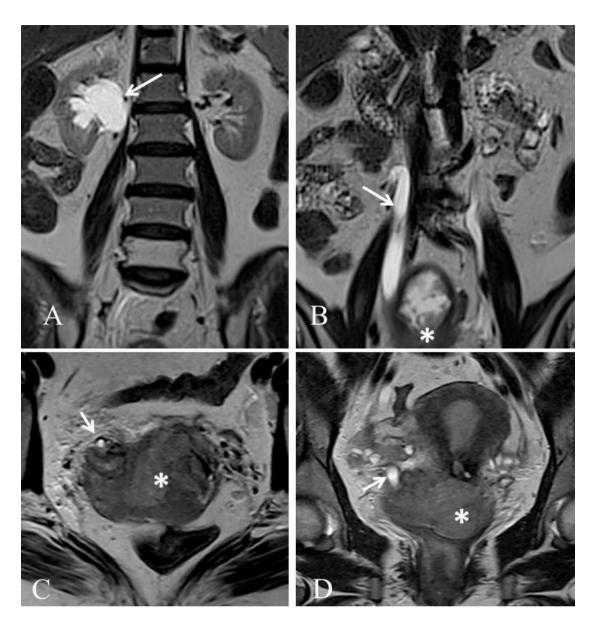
Coronal (A), (B), (D) and Axial (C) T2 weighted MRI showing cervical mass (white asterisk*) extending to bilateral parametrium and involving right distal ureter causing hydroureteronephrosis (white arrow), staged as IIIB.
